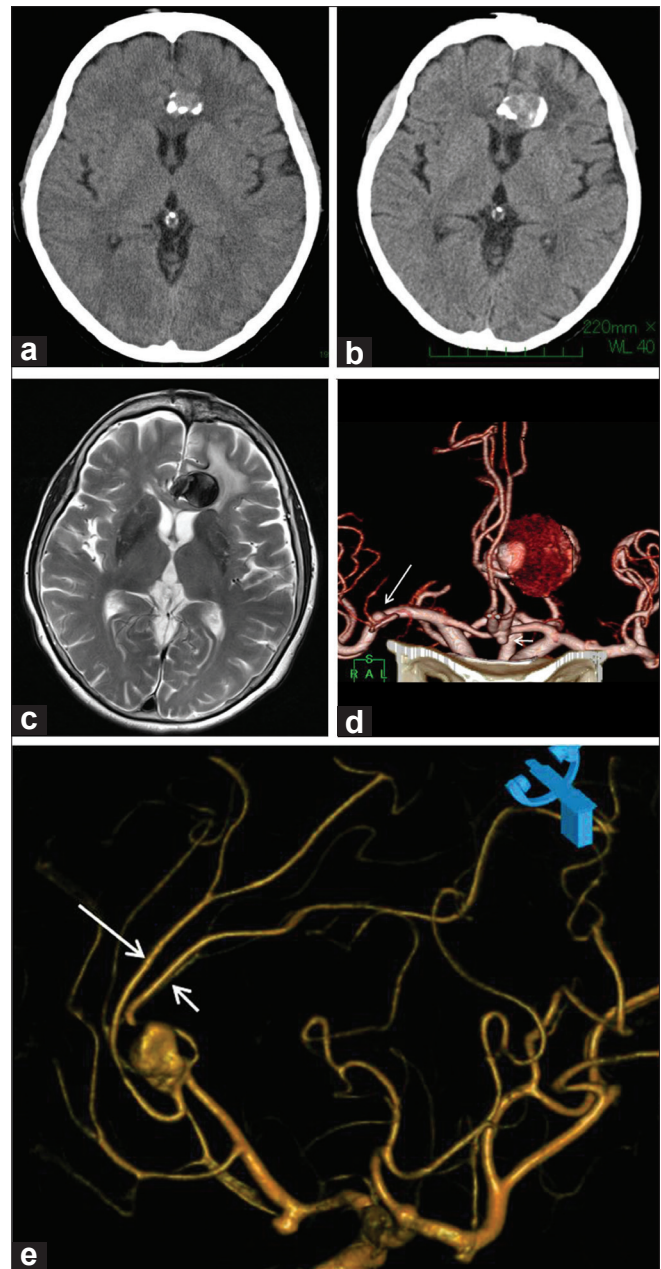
Follow-up images of the aneurysm. (a) Axial computed tomography scan before the first operation in 2003 showing a 15-mm heterogeneous mass in the left frontal lobe. (b) Axial computed tomography scan on admission in 2010 showing a 28-mm giant aneurysm with perifocal edema. The aneurysm is growing up with calcification. (c) Preoperative axial T2-weighted magnetic resonance imaging showing clear high signal intensity of marked perifocal edema in the white matter around the aneurysm. (d) The anteroposterior view of preoperative 3-dimensional computed tomography angiography showing three aneurysms, including a distal anterior cerebral artery aneurysm, an anterior communicating artery aneurysm (short arrow) and a right middle cerebral artery aneurysm (long arrow). (e) The left oblique view of preoperative 3-dimensional digital subtraction angiography of the left internal carotid artery showing the aneurysm at the pericallosal artery (PerA, short arrow)–callosomarginal artery (CMA, long arrow) junction
